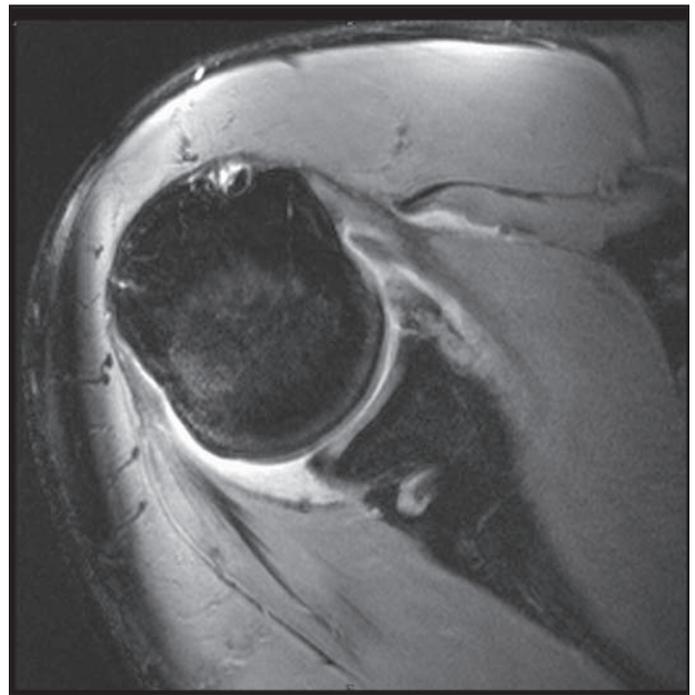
An axial slice MRI of an acute capsulolabral lesion immediately following a dislocation event. Note the disruption of continuity of the anterior capsule and labrum. This image also reveals a small Hill-Sachs lesion with the indentation of the posterior humeral head and underlying marrow edema. In this case, the acute effusion of the joint acts similar to contrast in highlighting particular structural injuries.
